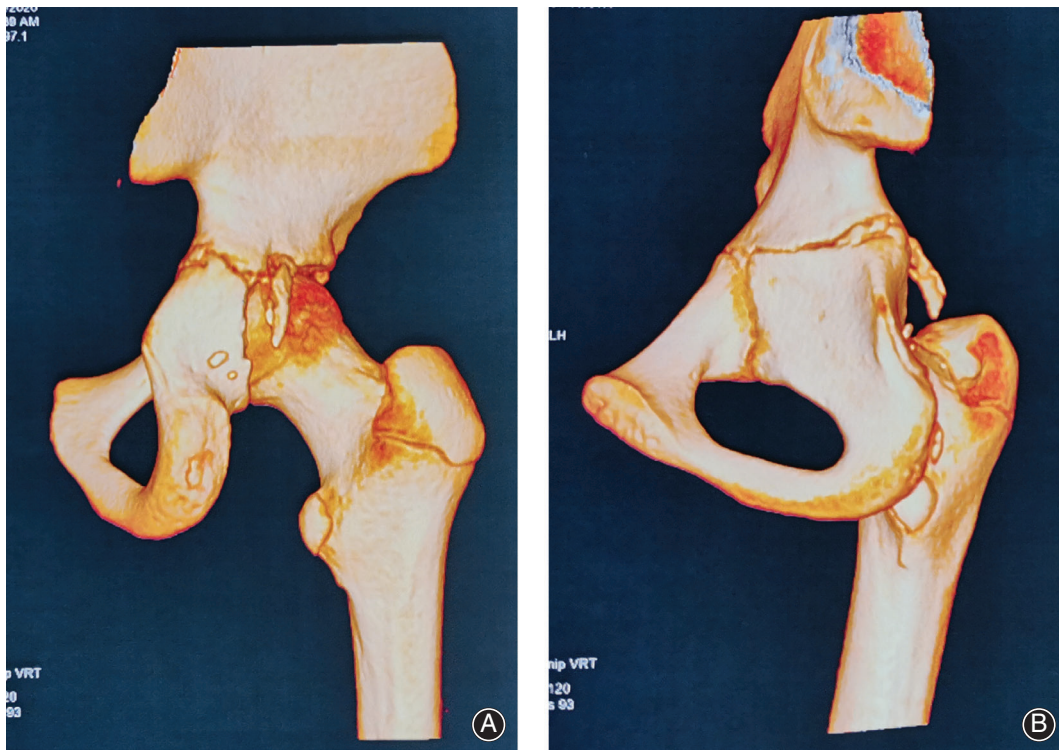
(A) Preoperative posterior view of 3D-CT showed the fracture of the acetabular posterior wall. (B) Preoperative posterior oblique view of 3D-CT showed the displaced of the major osseous fragment.
